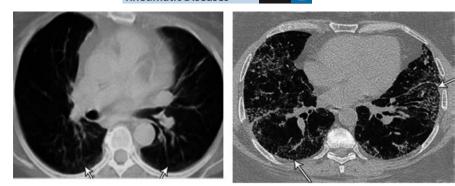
HRCT scans obtained at the level of the lower lobes of the Lungs in RA patient, showing reticulation and ground glass & honeycombing appearance in both lungs which are consistent with interstitial lung diseases
